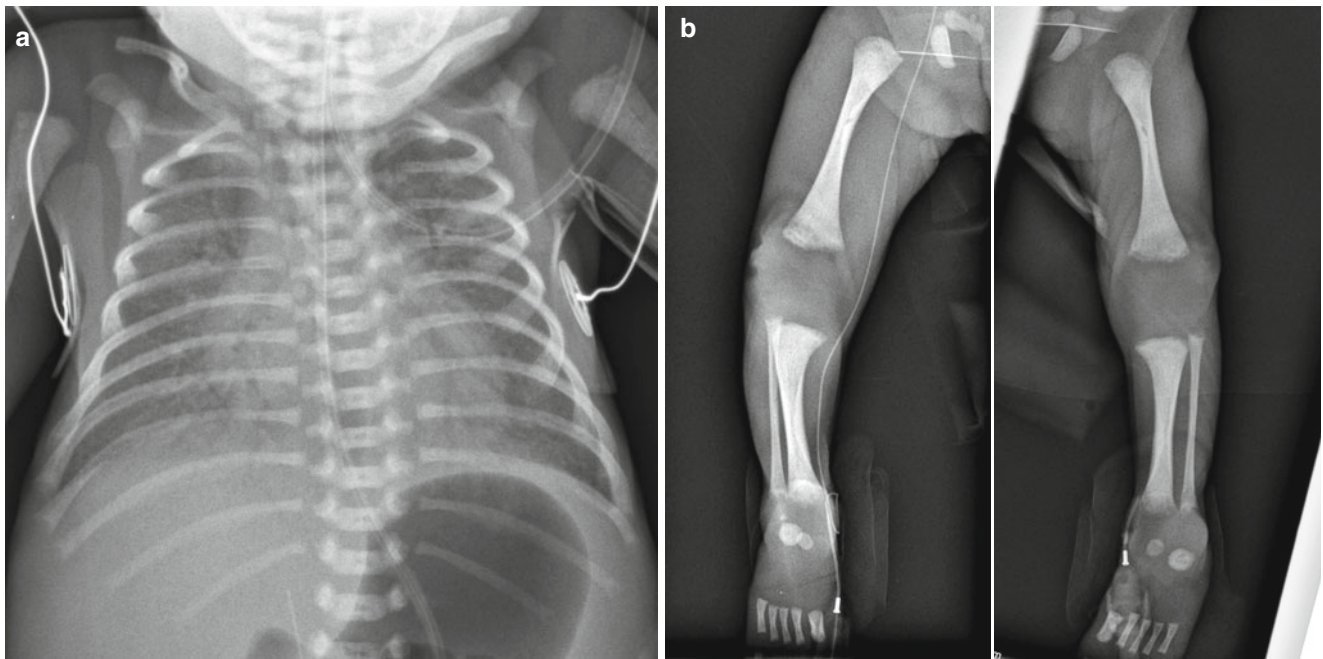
Pneumonia alba* in congenital syphilis in a 1-day-old pre-term neonate born at a gestational age of 32 weeks. (a) Anteroposterior radiograph of the chest demonstrates diffuse haziness in the lungs. Bilateral air bronchograms and mild cardiomegaly are also noted. The
